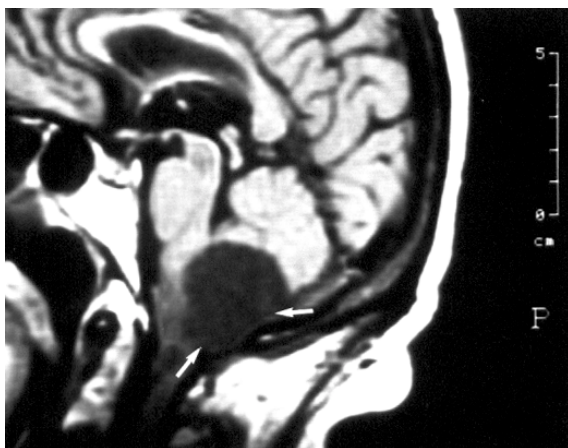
Unenhanced mid-sagittal T1W MR image through the inferior vermis shows a 4 cm diameter well-defined low signal intensity lesion extending to involve the tonsil (arrows). No intramural nodule is noted in this cystic astrocytoma.
